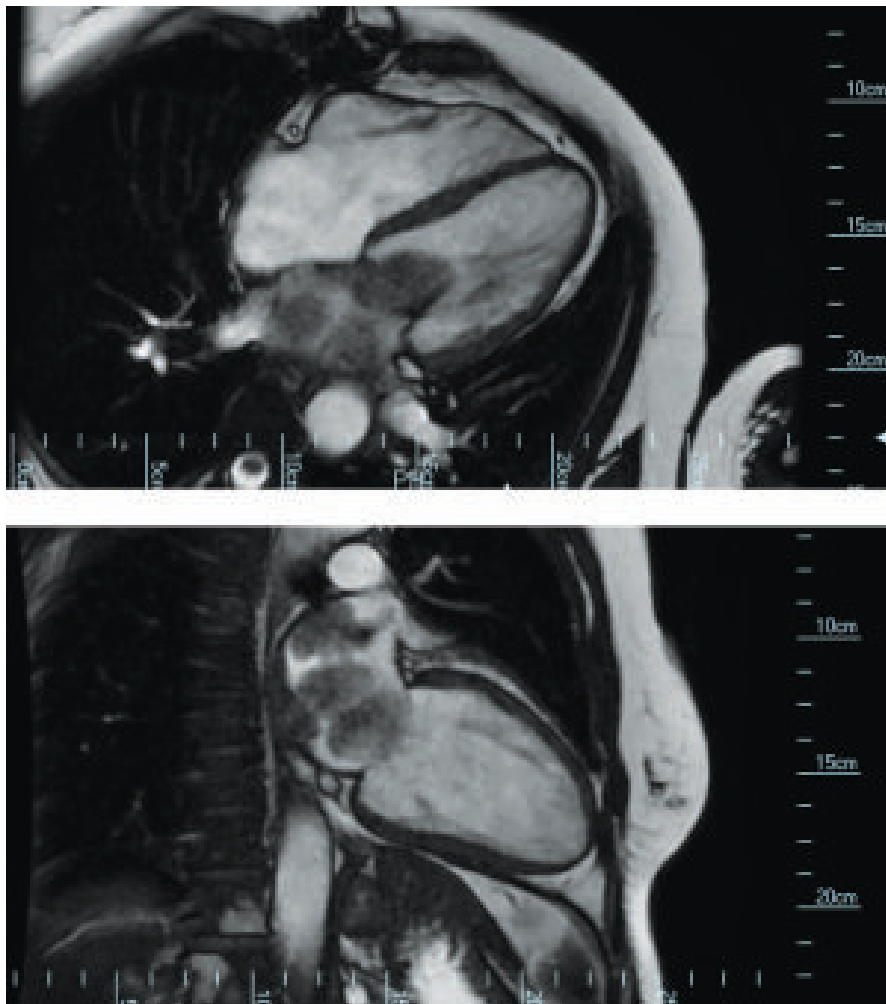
Cardiac MRI showing left atrial mass attached to mitral leaflet.
